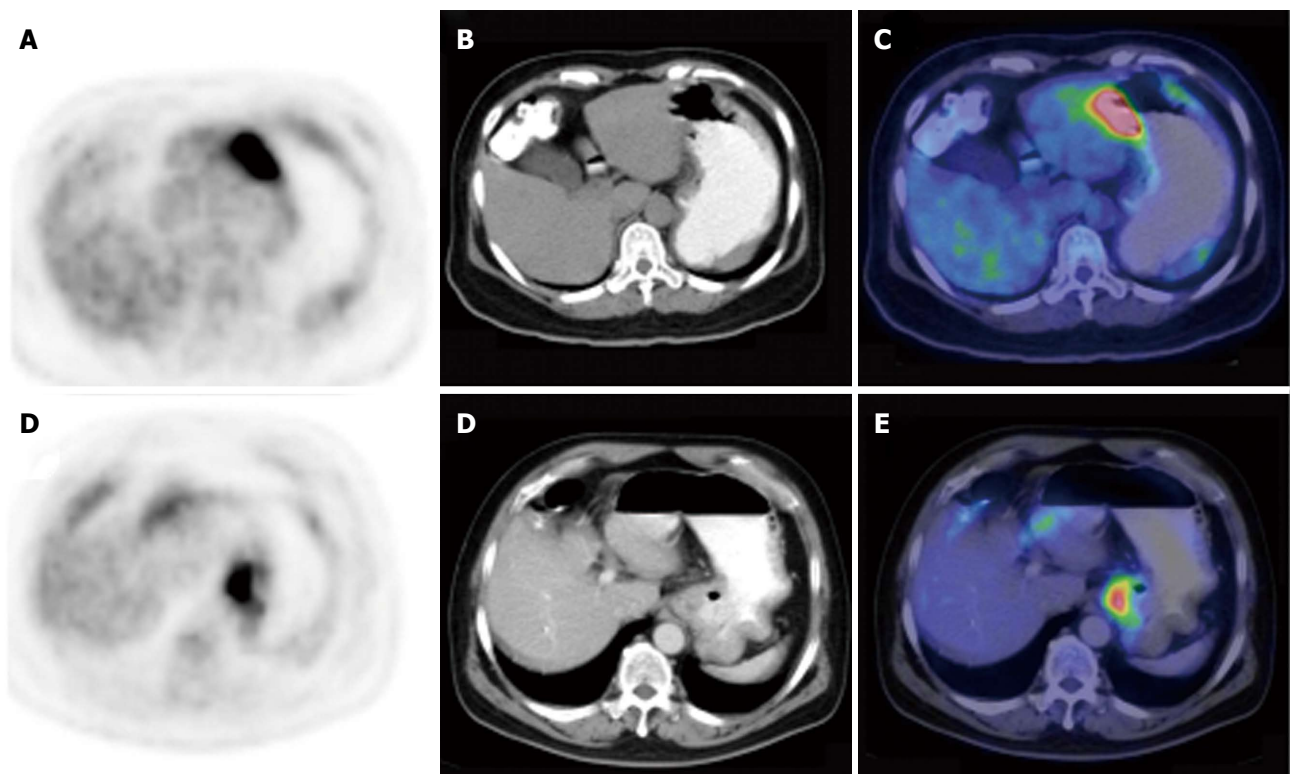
Comparison of gastric lymphoma and gastric carcinoma with local fluorodeoxyglucose uptake. A-C: PET (left column), CT (middle column) and PET/CT fused images (right column) of a 54-year-old woman with DLBCL (SUVmax 13.4, THKmax 2.0 cm); D-F: A 60 year-old man with poorly differentiated gastric adenocarcinoma (SUVmax 9.1, THKmax 1.9 cm) CT: Computed tomography; PET: Positron emission tomography; SUVmax: Maximal standard uptake value; THKmax: Maximal thickness.
